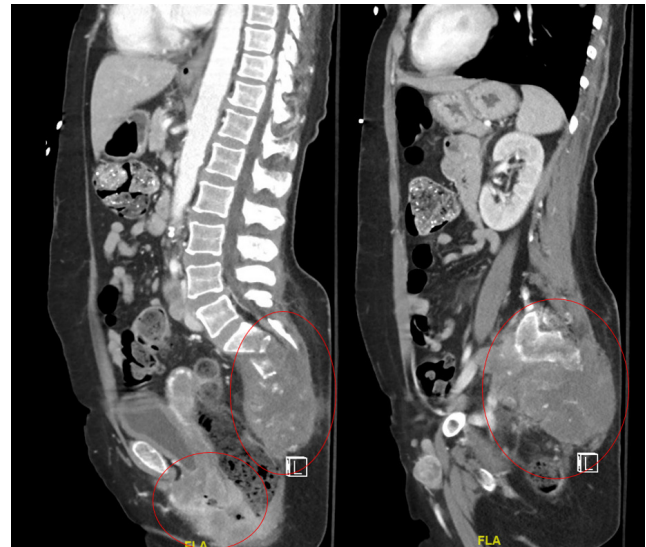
CT chest/abdomen/pelvis with and without contrast. Sagittal slices with a red circle showing large circumferential soft tissue mass extending to perineal soft tissues, vaginal cuff, and left gluteal fold. Large destructive soft tissue mass with significant osseous destruction of the sacrum and coccyx.
